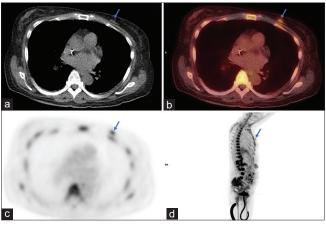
A 55-year-old woman with chronic intestinal pseudo-obstructions, fever, nausea, vomiting, and diarrhea. <sup>18</sup>F-FDG PET/CT scan shows (a) nodular opacity in the medial left breast on CT, with (b-d) intense <sup>18</sup>F-FDG uptake (arrow). Gastrointestinal symptoms gradually resolved after patient underwent surgery, chemotherapy, and radiation therapy for invasive ductal breast carcinoma
